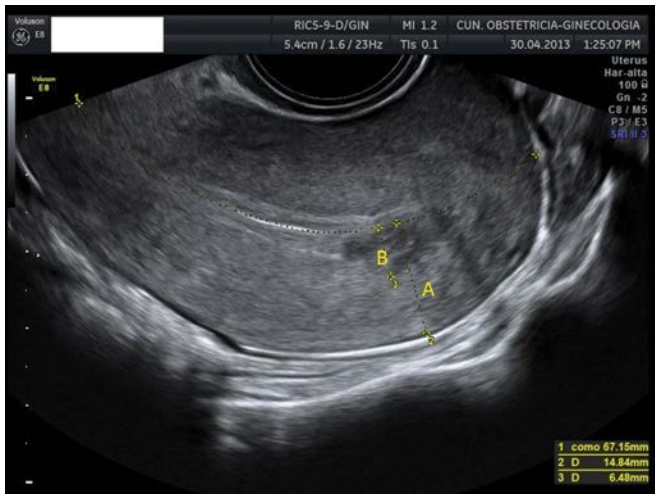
Transvaginal ultrasound showing the Gordon method for assessing myometrial infiltration in endometrial cancer. In this case, the ratio B/A is 0.44, suggesting superficial infiltration (<50%).
